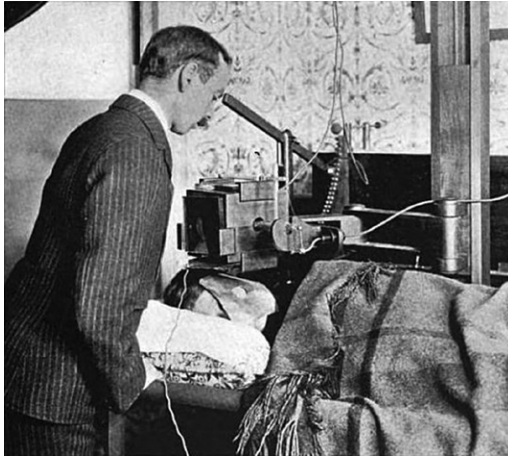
An early radiotherapy machine delivering low energy X-rays with shielding of the face by a thin layer of lead. Reproduced from Williams [4].
